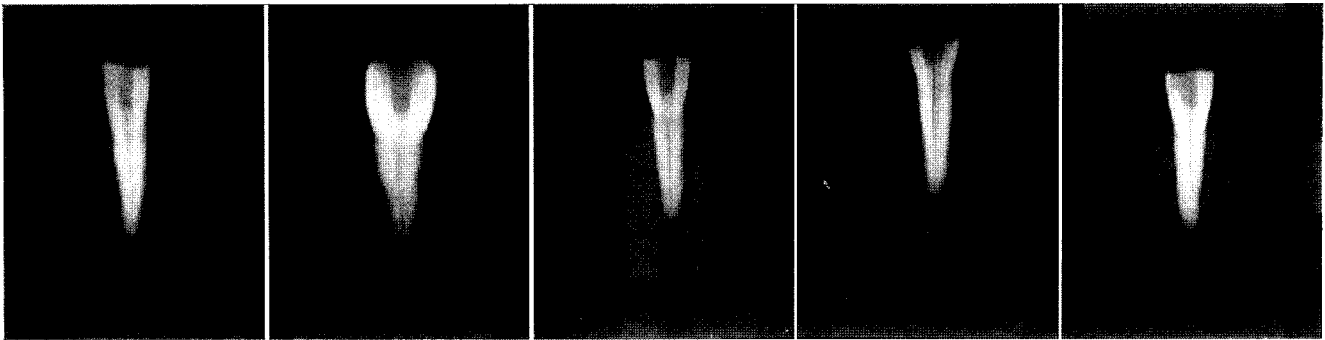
Radiographs show the images of a fractured tooth using the film-based conventional system.
